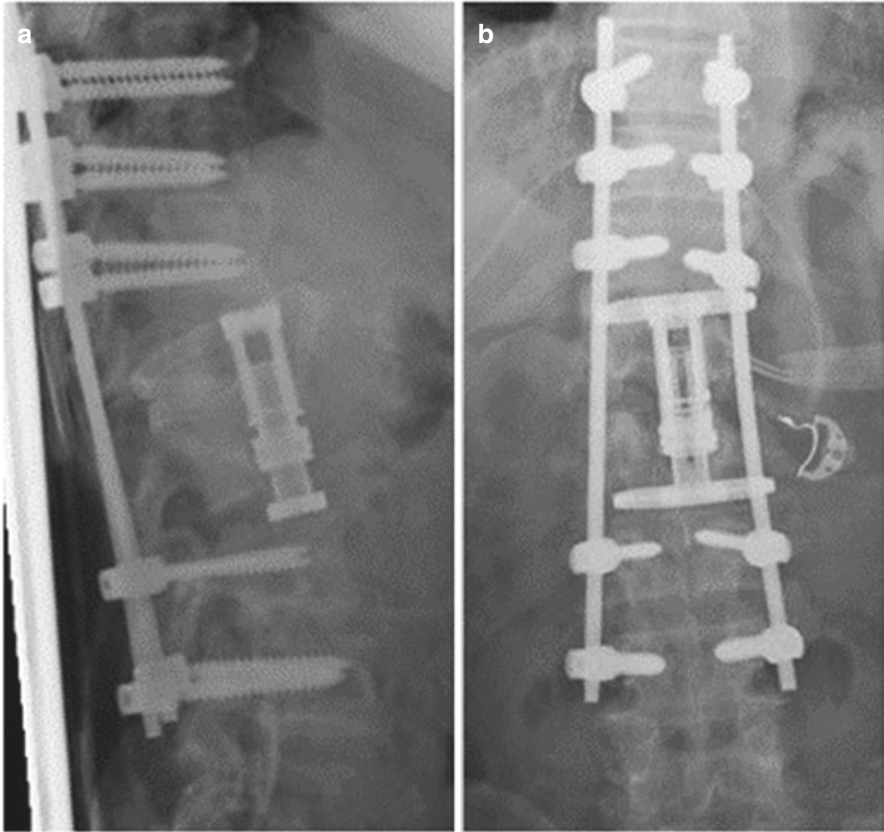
Postoperative lateral (a) and AP (b) x-rays of the thoracolumbar spine showing the titanium expandable corpectomy cage at L1-L2 and posterior fixation with pedicle screws from T10-L4
